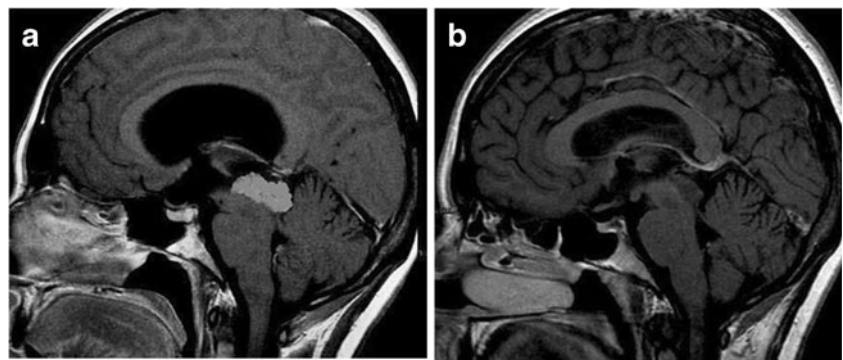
Case of a posterior third ventricle neurocytoma. a Preoperative sagittal T1-enhanced MRI showing a posterior third ventricle neurocytoma. b Postoperative 2-year F-U sagittal T1-enhanced MRI showing a complete removal
